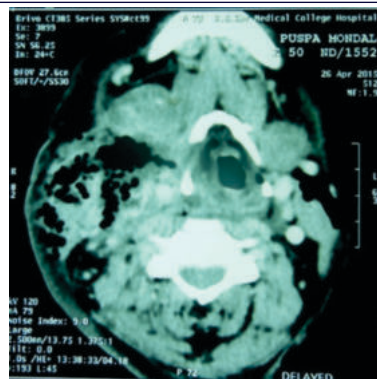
CT scan (Transverse) showing gas in subcutaneous tissue plane in infratemporal region and cervical region
